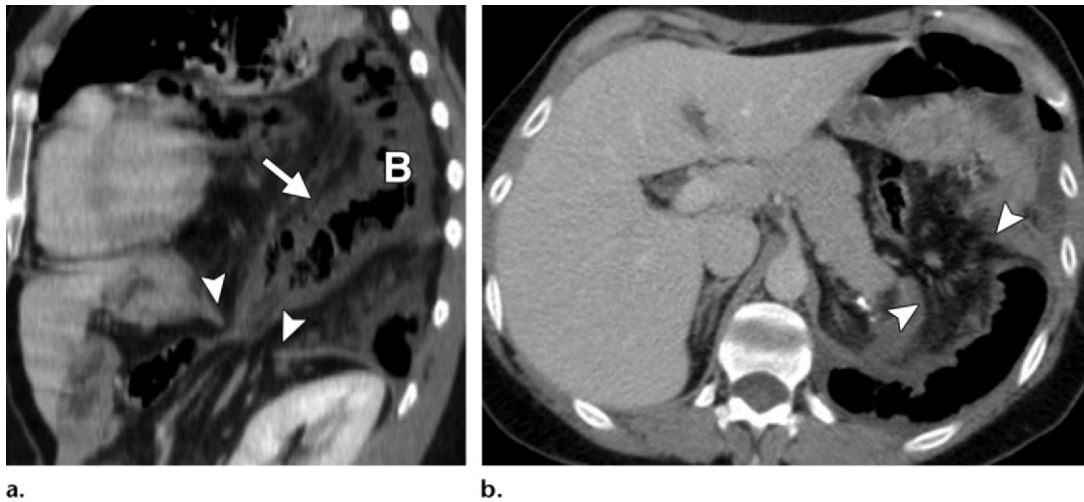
Bowel strangulation in a 19-year-old woman with severe abdominal pain and sepsis 7 years after severe blunt trauma. (a) Sagittal contrast-enhanced reformatted CT image shows left-sided BDR, depicted as a 3-cm-long segmental diaphragmatic defect (arrowheads) through which a bowel loop (*B*) bulges into the thorax. The hernia is evident from the waistlike constriction of the bowel at the level of the diaphragm (collar sign). Thickening and hypoenhancement of the herniated bowel wall (arrow) are suggestive of strangulation. The herniated abdominal contents are positioned against the posterior wall of the thorax (dependent viscera sign). (b) The collar at the base of the herniated bowel (arrowheads) is more difficult to detect on the axial CT image than on reformatted images in other planes. Bowel edema without ischemia was found at surgery. (Case courtesy of Mostafa El Hajjam, MD, Club Thorax, Paris, France.)
